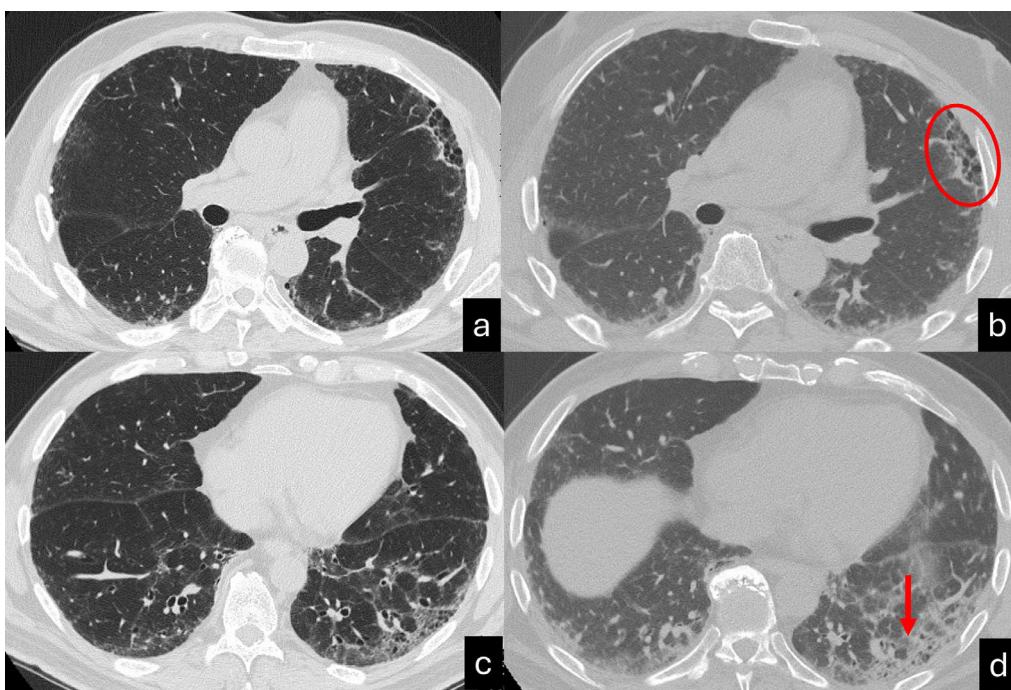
Inspiratory (a,c) and expiratory CT scan (b,d) shows UIP pattern characterized by the presence of honeycombing in the anterior segment of the left upper lobe, traction bronchiectasis and focal fibrotic ground glass in the left lower lobe. A mild peripheral reticulation is also present in the right lung parenchyma. The expiratory scan (b,c) shows a homogenous reduction in lung volumes associated with a diffuse increase of the lung density, in absence of air trapping. Interestingly, the area of honeycombing doesn't collapses (red ellipse). Moreover, the focal ground glass surrounding traction bronchiectasis, shows a lack of traction bronchiectasis collapse (red arrow).
